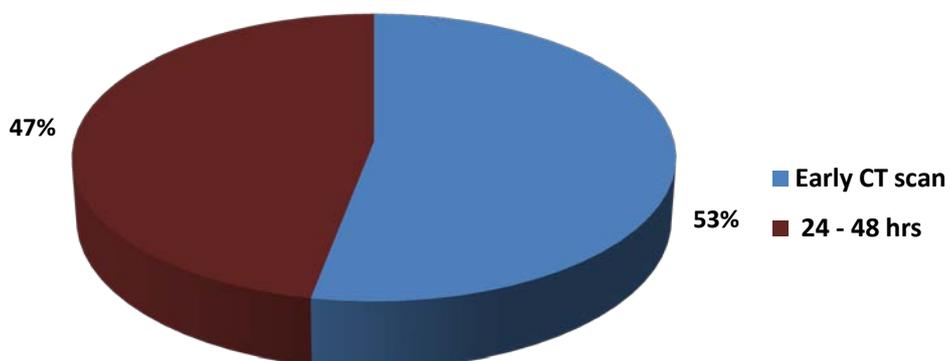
Percentage distribution of patients with stroke according to the time of CT performance.
